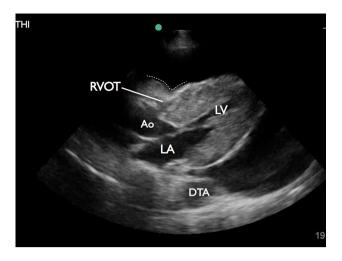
Pericardial effusion and tamponade. This parasternal long view of the heart was obtained by placing the phased array probe to the left of sternum at approximately the fourth intercostal space with the indicator pointed toward the patient's right shoulder. The left atrium (LA), left ventricle (LV), aorta (Ao), right ventricular outflow tract (RVOT), and descending thoracic aorta (DTA) are all seen in this image. This parasternal long view demonstrates right ventricular diastolic collapse as evidenced by the inward scalloping of the free wall of the right ventricle (*dashed white line*) and near complete compression of the RVOT. The heart is surrounded by a circumferential pericardial effusion which is anechoic (*black*). An incidental finding of left ventricular hypertrophy, with the left ventricular wall appearing to have a thickness over 1 cm, is also seen. [See Supplemental Video 6]
